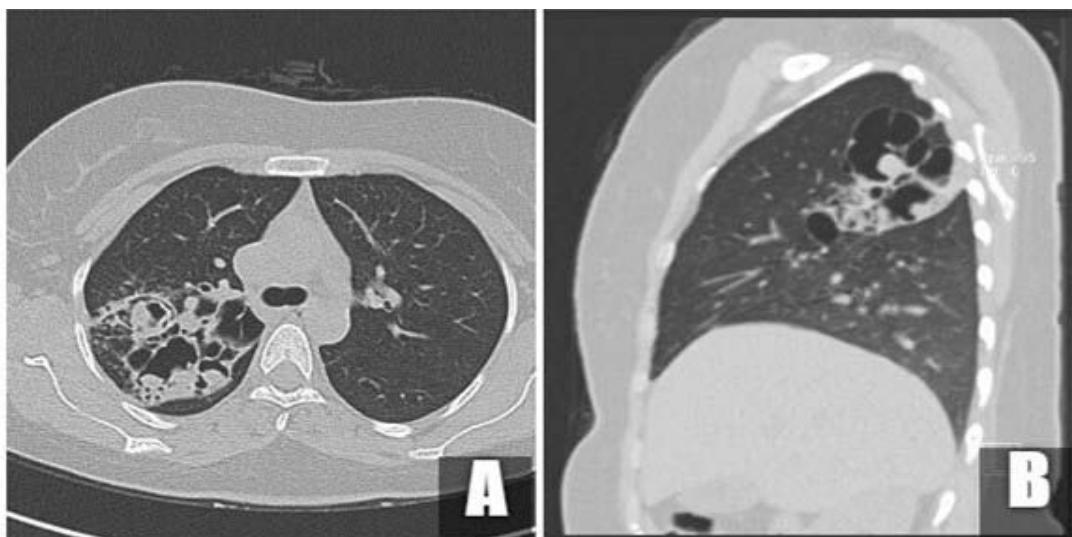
CT with contrast showed tree-in-bud sign associated with severe cystic bronchiectasis involving the right upper lobe posterior segment. Tiny multiple middle lobe nodules accompanied by mild bronchial wall thickening are also seen
